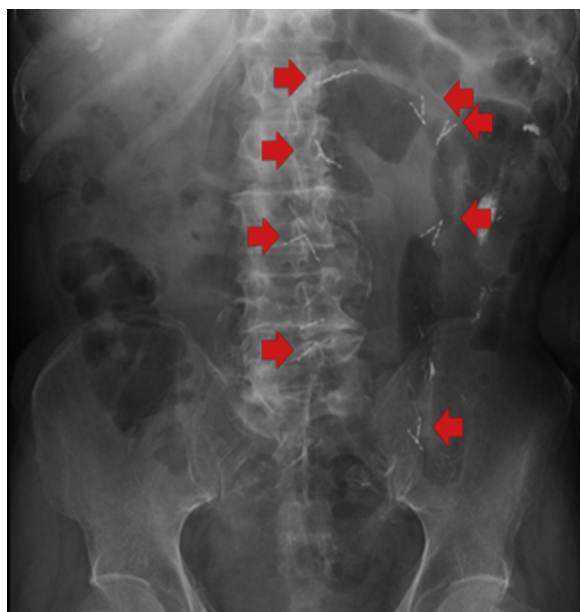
Abdominal radiograph showing the devices for fixation to the abdominal wall (red arrows).
